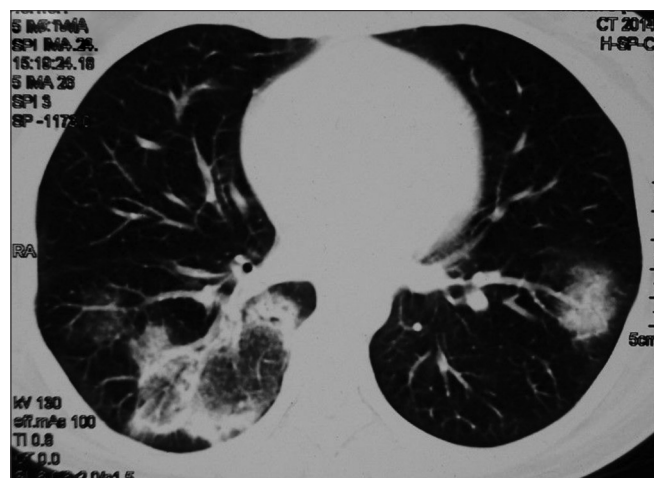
High-resolution computed tomography thorax image (lung window section) showing bilateral lower lobe consolidation with central ground-glass opacity and denser peripheral rim of consolidation suggestive of reversed halo sign
